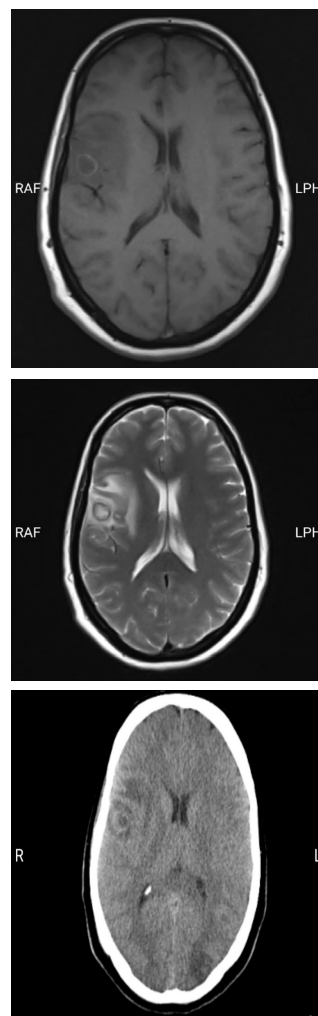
T1- weighted MRI image of brain of the index case demonstrating the right temporal ring-enhancing lesion with surrounding vasogenic edema suggestive of brain abscess.
